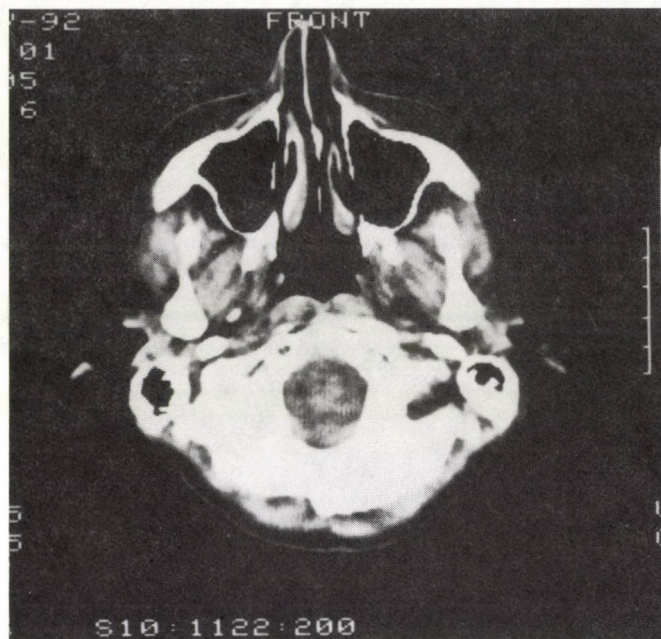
CT scan made 2 years following radiotherapy demonstrates complete regression of the tumour
